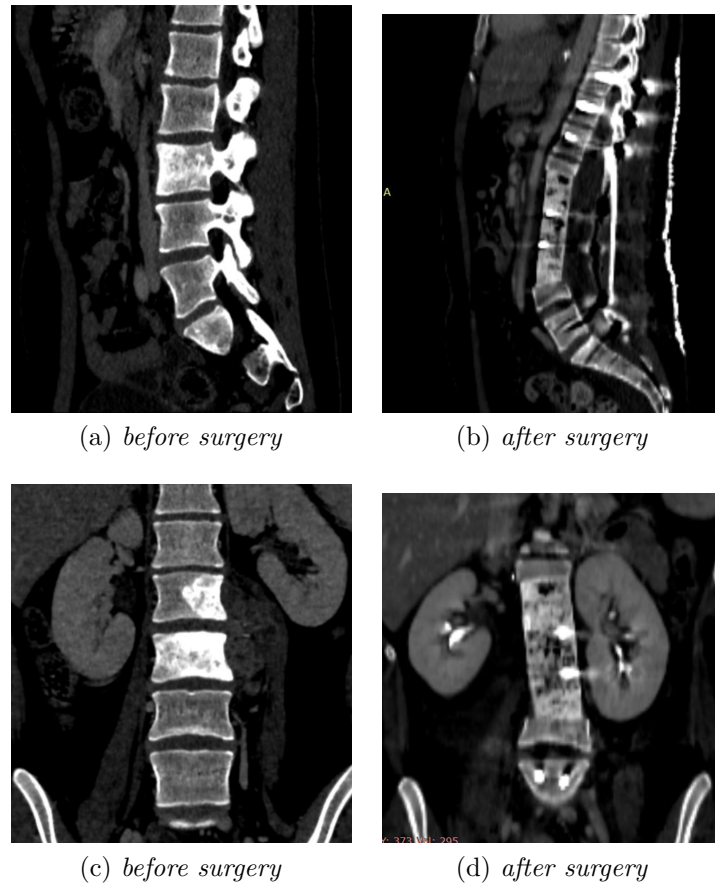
CT images before and after surgery
